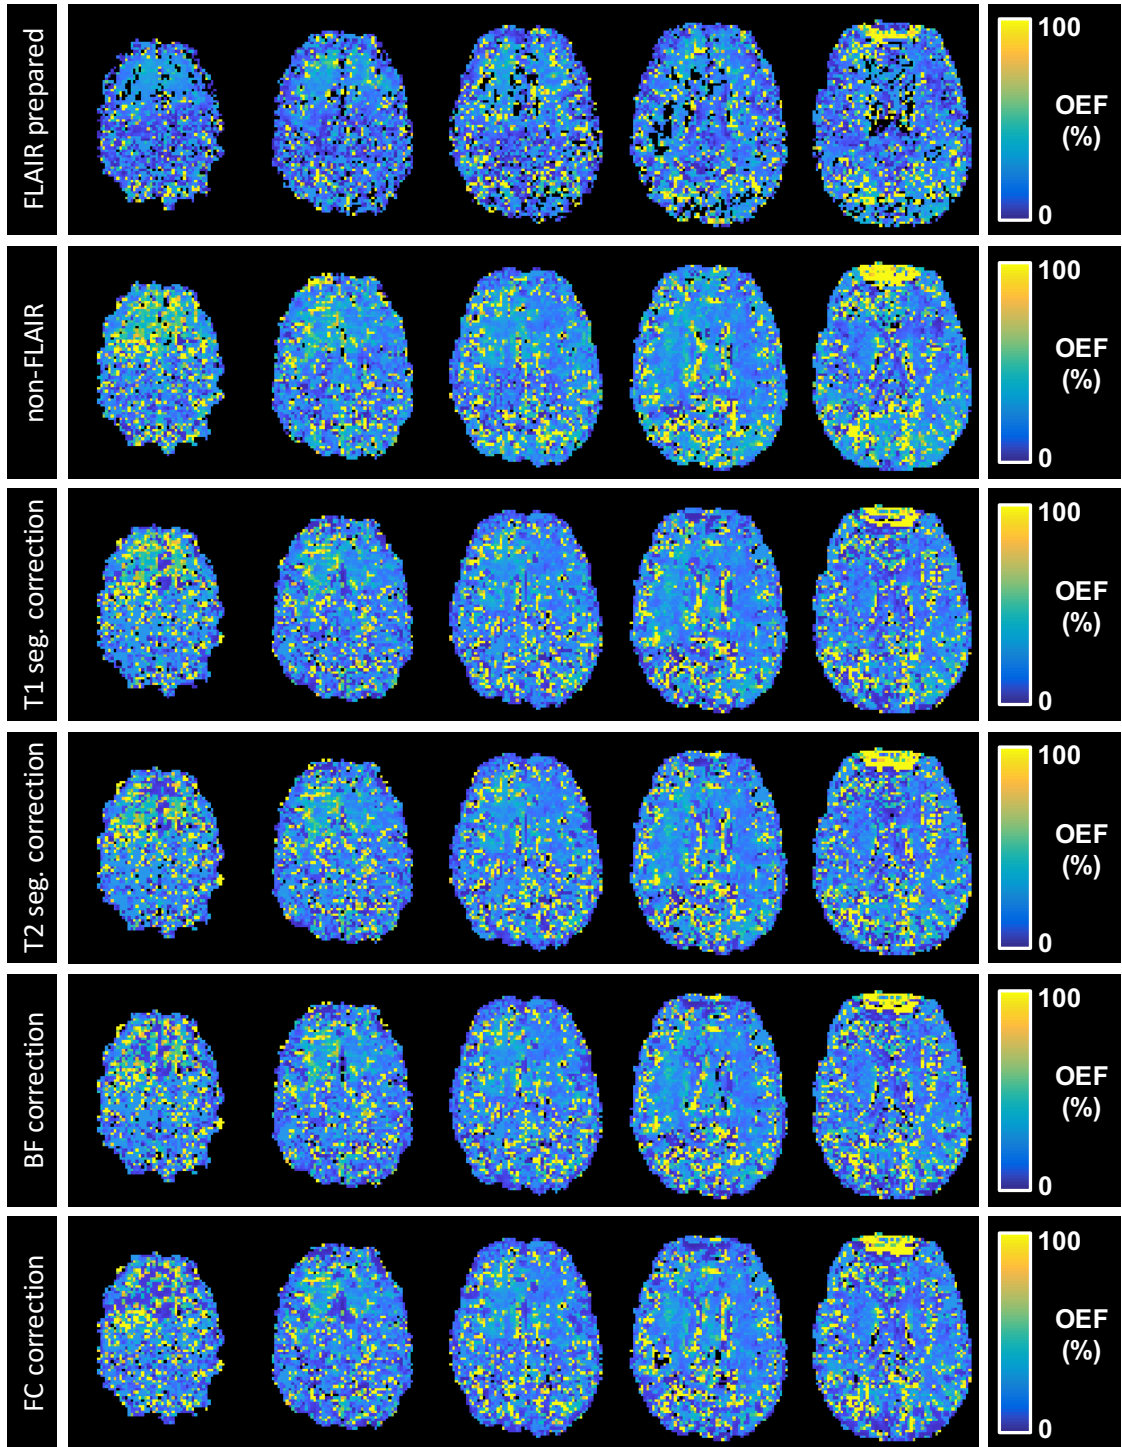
Example maps of estimated OEF from a single subject, under different conditions of CSF correction: First row: FLAIR-prepared acquisition; Second row: non-FLAIR acquisition (uncorrected 3C model); Third row: non-FLAIR acquisition with CSF correction using segmented T_1 data; Fourth row: non-FLAIR with T_2 segmentation CSF correction; Fifth row: non-FLAIR with biexponential fit CSF correction; Sixth row: non-FLAIR with FLAIR-contrast correction.
